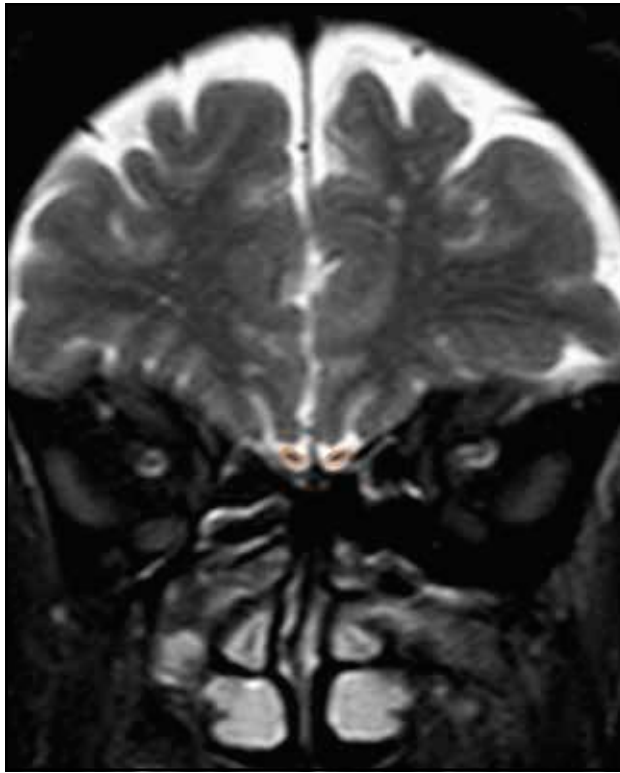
On coronal T2-weighted MRI images, OB volume measurements are shown (orange circles).
